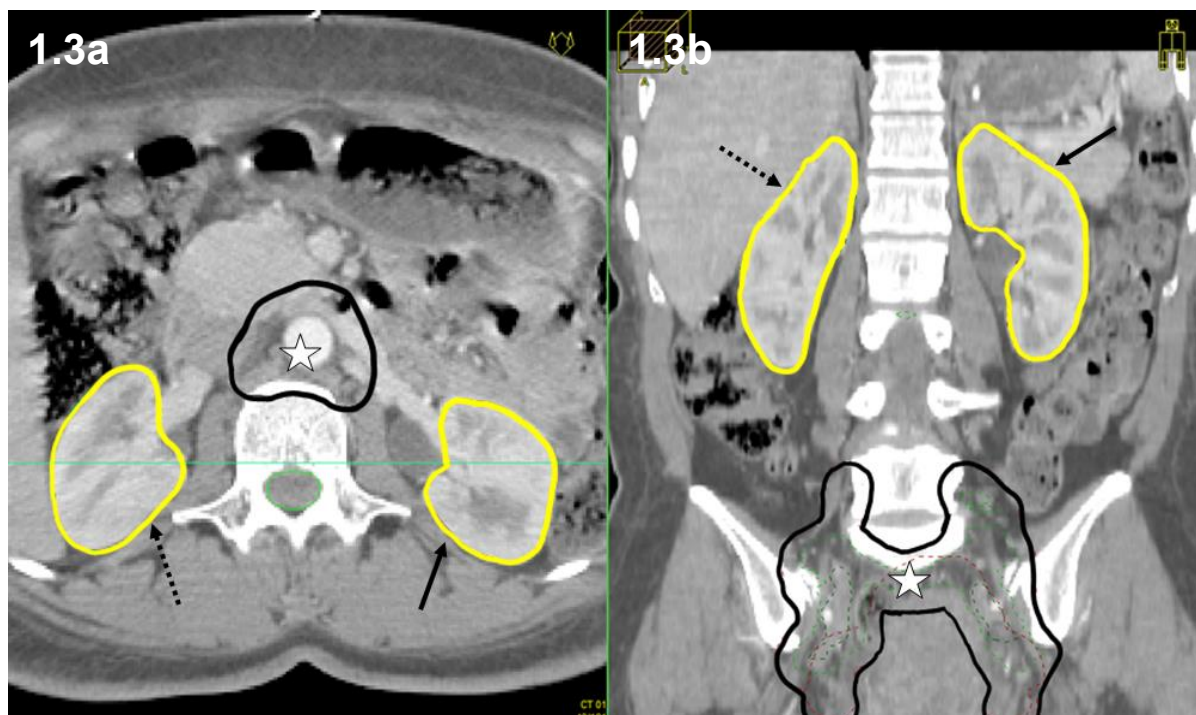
Transverse (a) and coronal (b) CT of patient receiving para-aortic nodal radiotherapy (PTV starred) with left kidney (solid arrow) and right kidney (dashed arrow) outlined.
